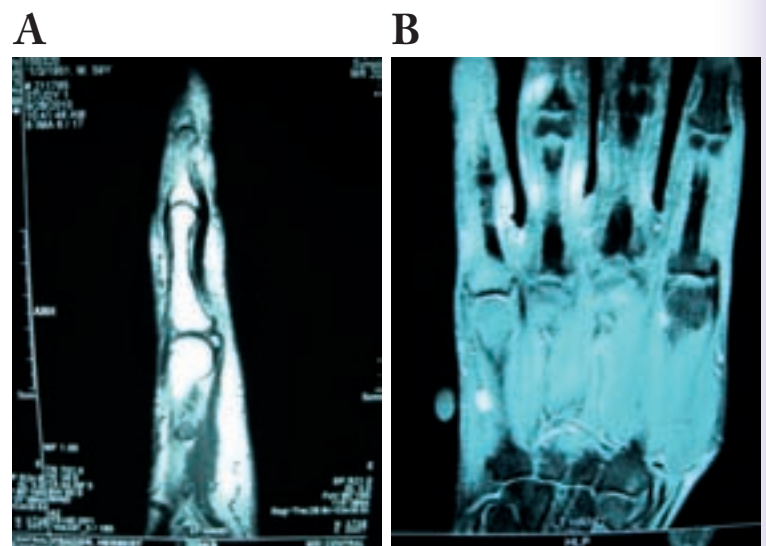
Magnetic resonance imaging demonstrating signal change and mass along the ulnar border of the small finger metacarpal. a. T-1 weighted image b. T-2 weighted image.
